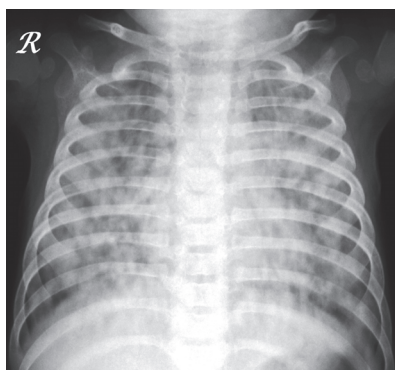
Chest radiograph in AP projection shows diffuse pulmonary infiltrative opacities in both lung fields in a case of bacterial pneumonia.
